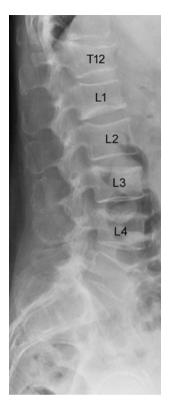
Lateral radiograph of the lower thoracic and lumbar spine of a 63-year old woman with osteoporotic vertebral fractures from T12 to L4
